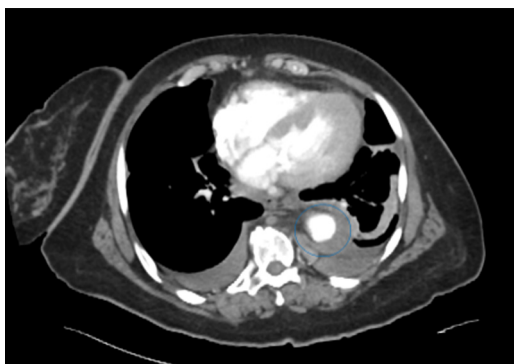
Chest X-ray and CT Scan Following Perforation
